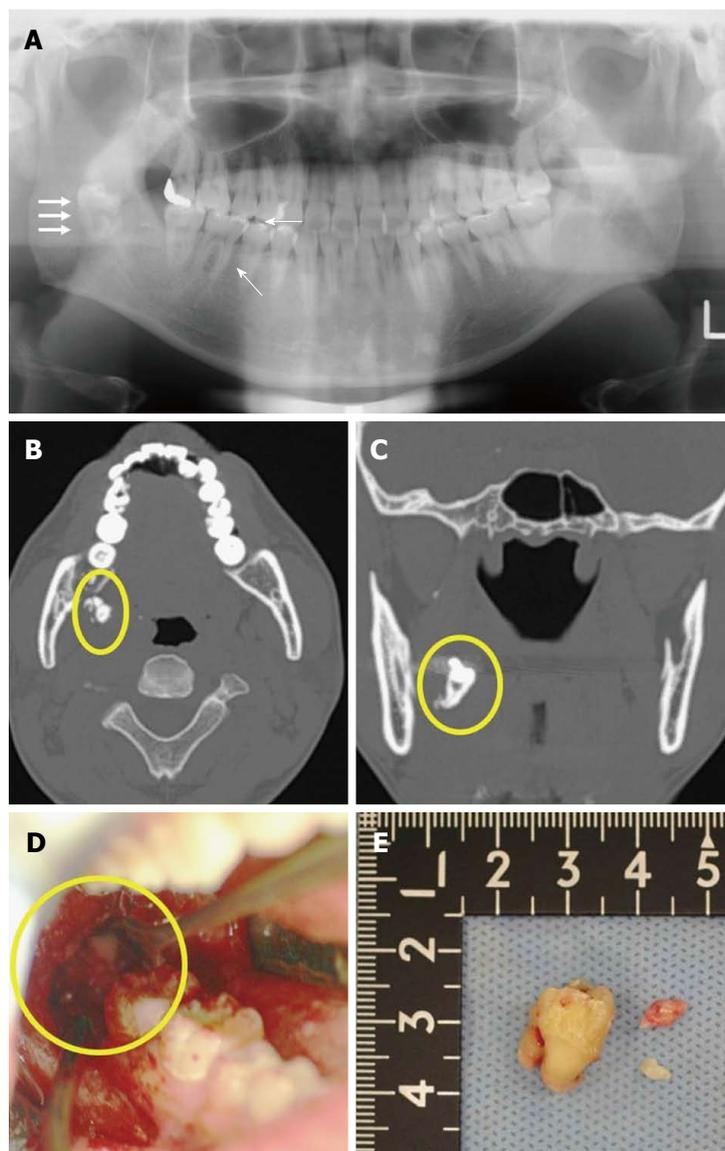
Imaging and surgical removal of a dislocated third mandibular molar (LM3). A: Orthopantomography showing a dislocated LM3 during surgical removal. The dislocated LM3 is superimposed over the middle part of the mandibular ramus (white arrows); B: Axial multi-detector computed tomography (MDCT) image and C: coronal MDCT image of the dislocated LM3 deviating into the pterygomandibular space (yellow circle); D: Surgical extraction; E: Extracted LM3.
